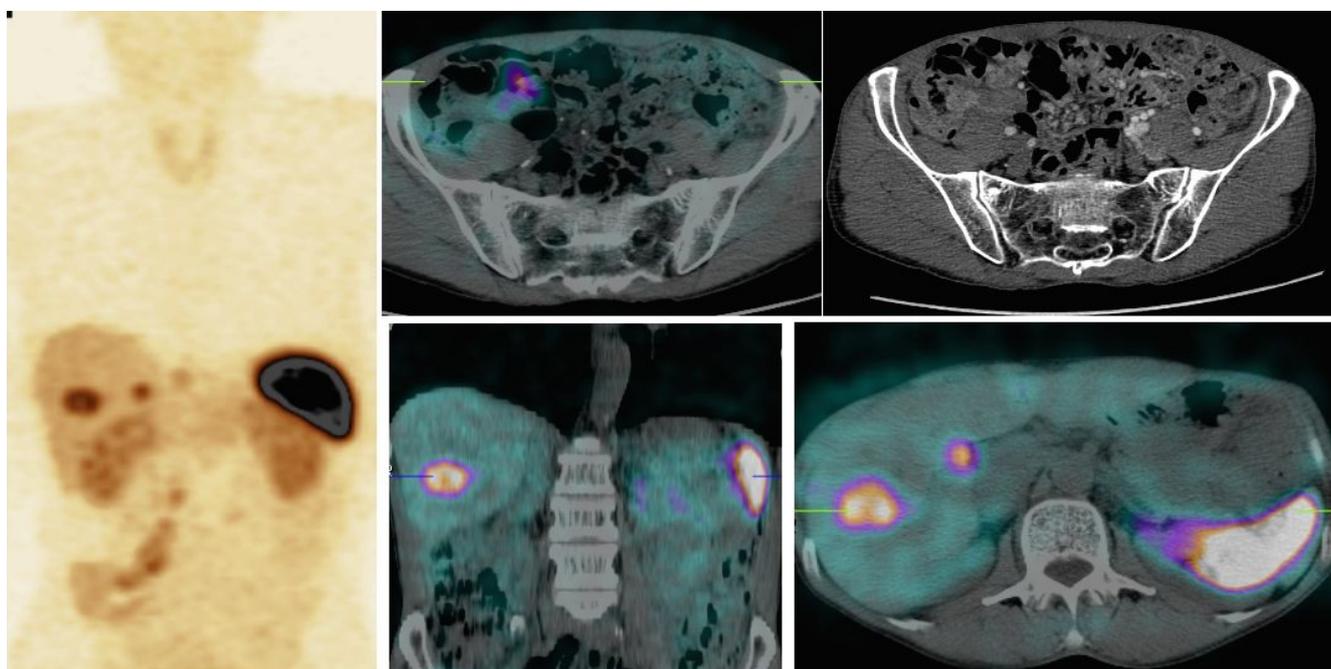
Example images generated by SRS using ^{99m}Tc HYNICTOC (Tektrotyd, PL) and whole-body SPECT/CT on a 64 year old male with NENG2 and after right hemicolectomy (Ki-67 8%; pT3N1M1, CS IV at baseline, size of the tumour – 23 mm).
